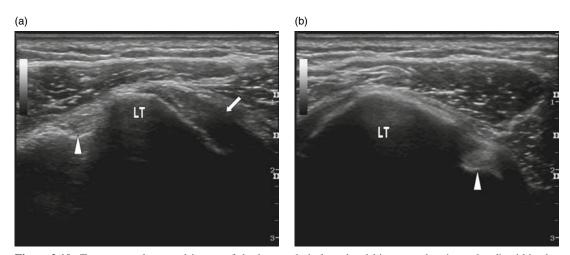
Transverse ultrasound image of the hyperechoic long head biceps tendon (arrowhead) within the bicipital groove on (a) internal rotation and (b) external rotation. LT, lesser tuberosity; arrow, subscapularis tendon.
